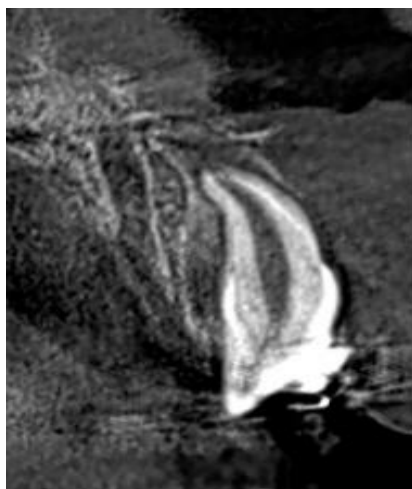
CBCT image revealing corono-radicular dilaceration with abnormal angulation of crown and root of tooth 21.
